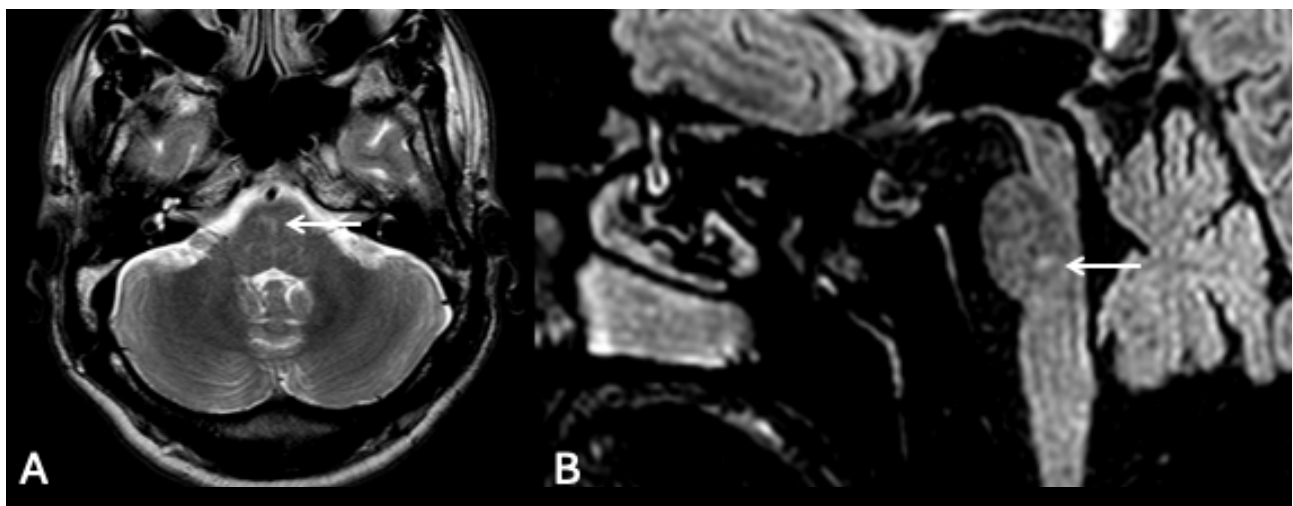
MRI of a 27-year-old man presenting with cognitive-behavioral impairment and headache. Axial T2WI and sagittal FLAIR sequences (A and B, respectively), showing hyperintense foci in the ventral pons (arrows), indicative of vasculitis in BD.
